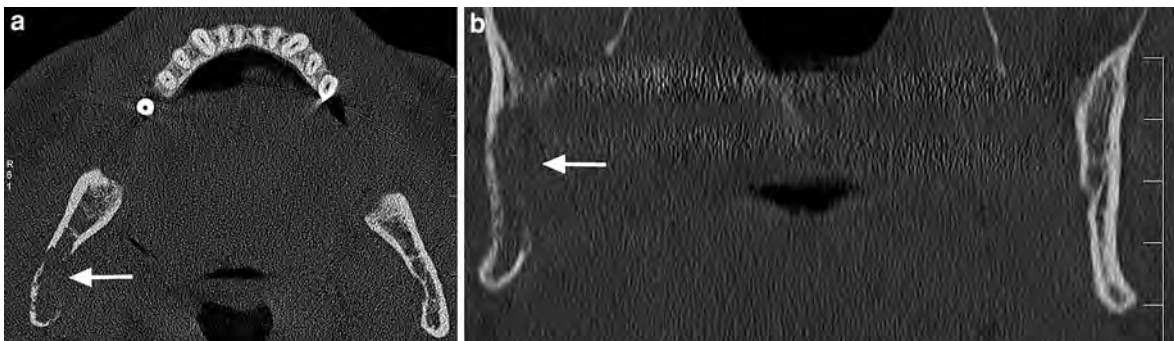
Malignant secondary lesion of the right mandible in a 55-year-old female with dysaesthesia of the right V3 territory. a, b Axial and coronal CT image in bone-window-level-setting
